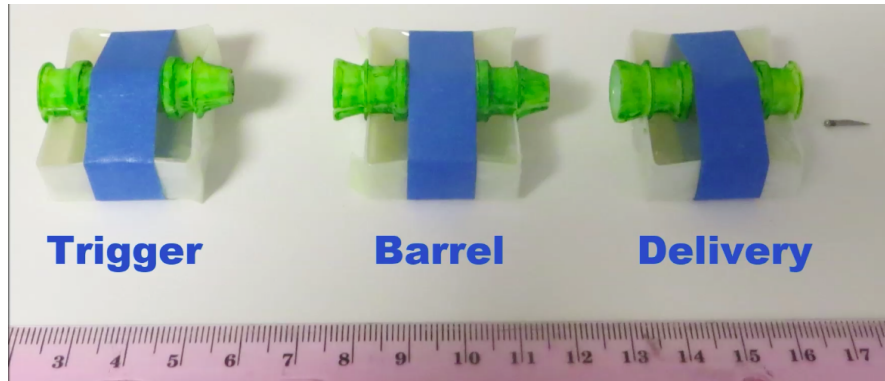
Gauss gun components used in MRI experiments
